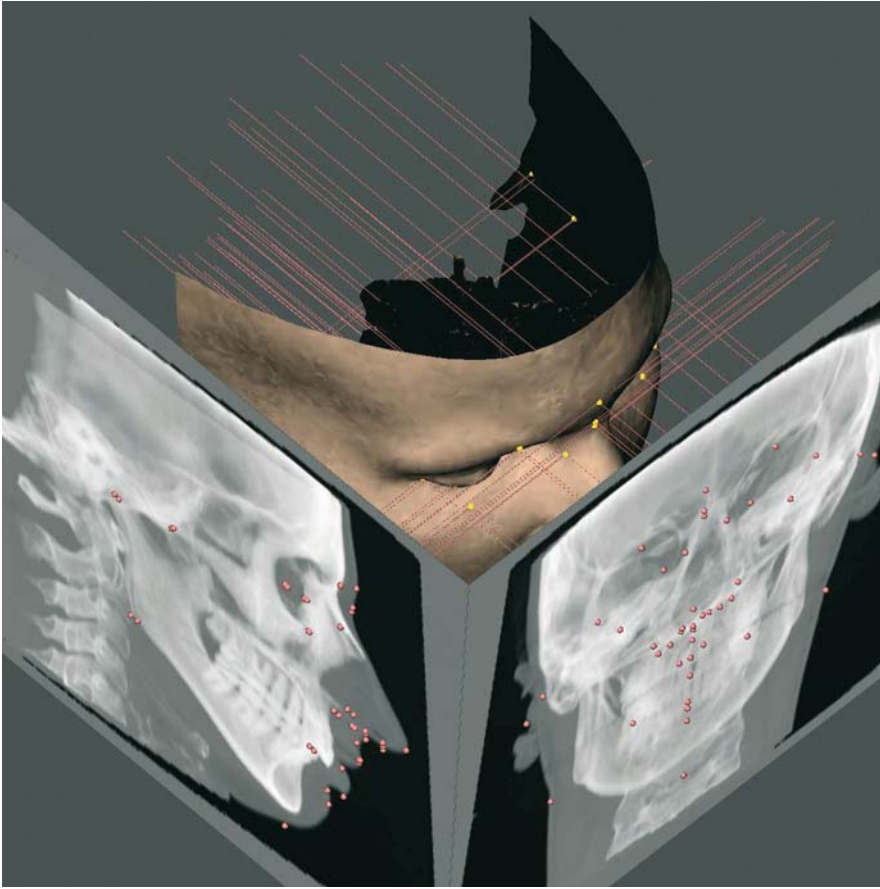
Set-up of 3-D cephalometric soft tissue landmarks. Virtual lateral and frontal cephalograms linked to the 3-D soft tissue surface representation (3-D CT, patient K.C.)
